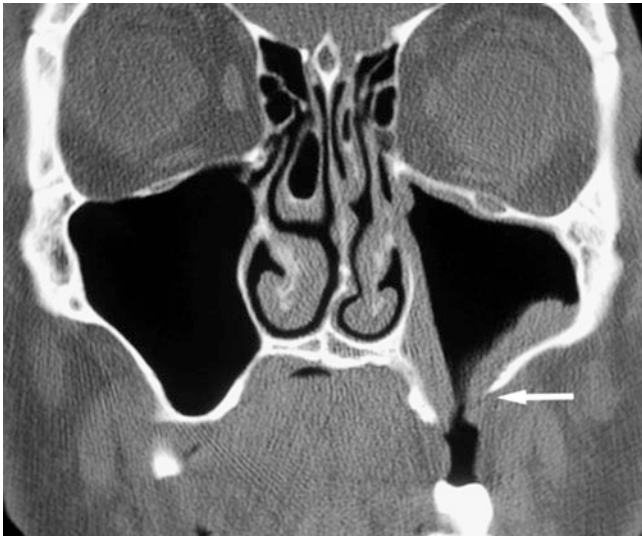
Oroantral fistula; patient with history of previous problematic tooth extraction. Coronal CT shows opening between the oral cavity and maxillary sinus (*arrow*) and minimal mucosal thickening
